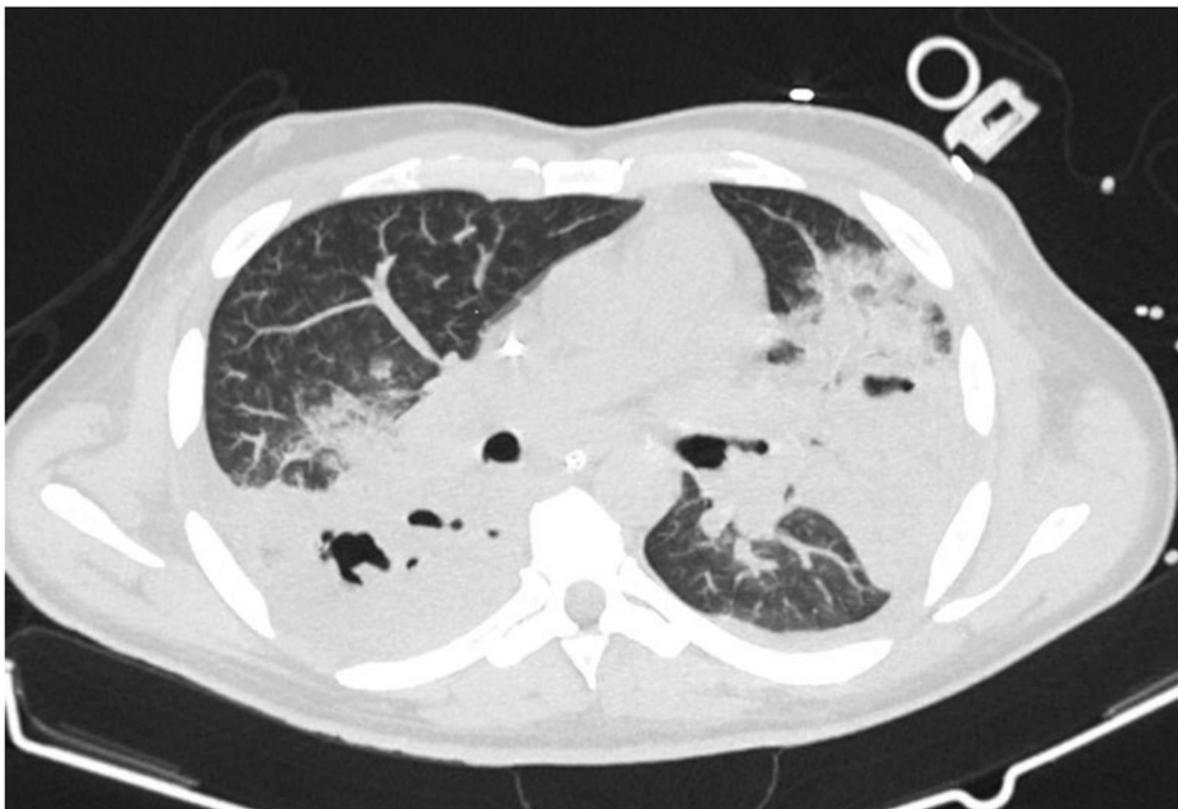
Chest CT on the 9th day.
